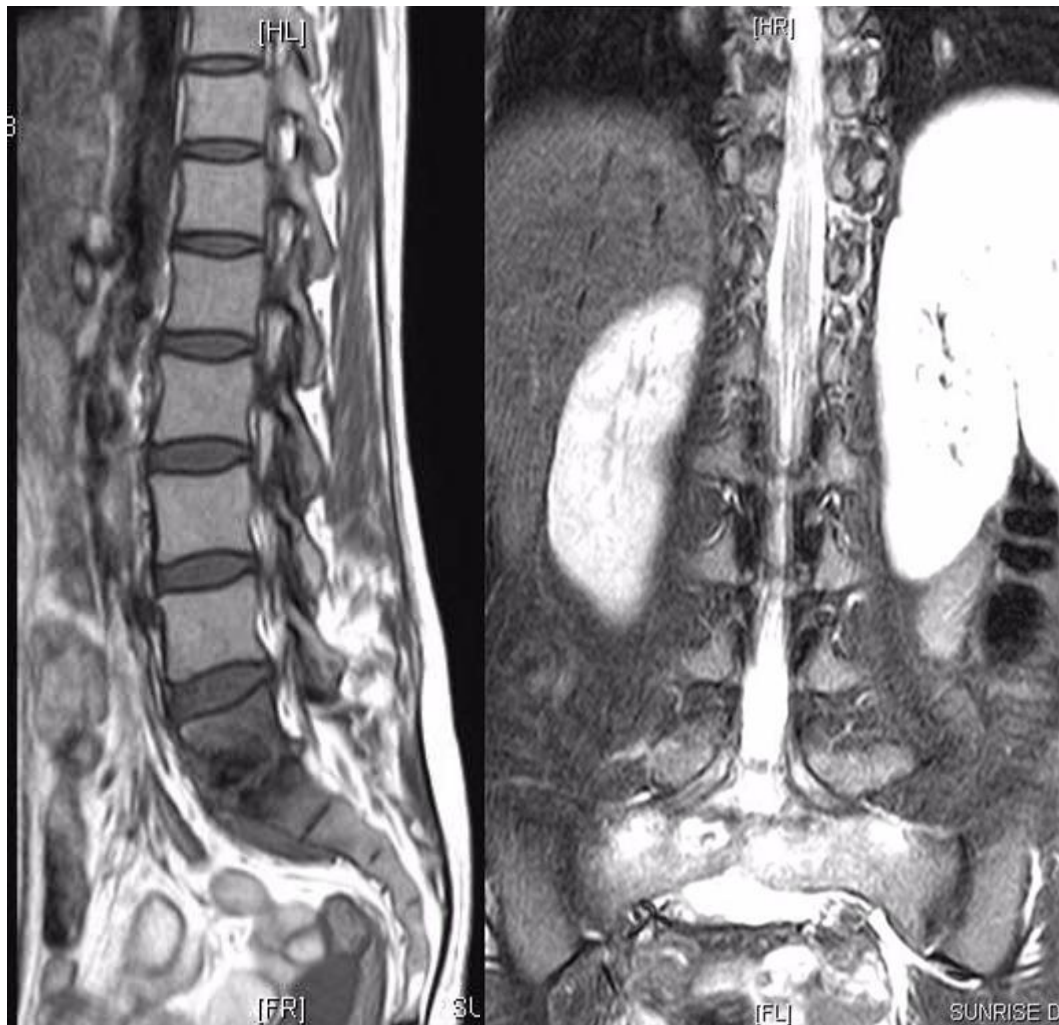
MRI of lumbosacral spine spine T1-weighted saggital image showing disc dessication along with disc destruction at level of L5-S1. Also noted are hypointense signal changes in L5 and S1 vertebral body predominately in paradiscal region. Similar changes can be seen on coronal section
